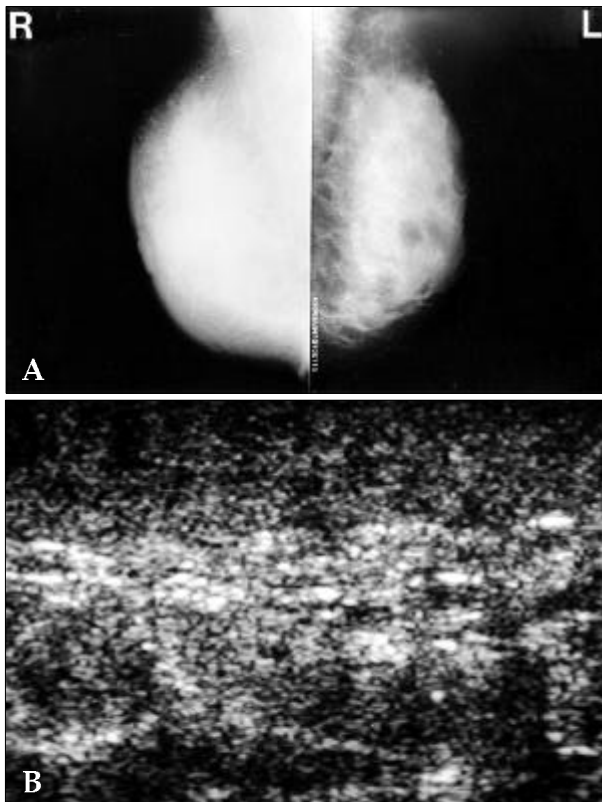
Lymphangitic metastasis to the breast from stomach cancer in a 23-year-old woman. (A) Mediolateral oblique mammograms demonstrate that the right breast is much denser than the left and its skin is thickened. (B) Ultrasound of the right breast shows diffuse skin thickening and obliteration of subcutaneous fat without evidence of any mass.
